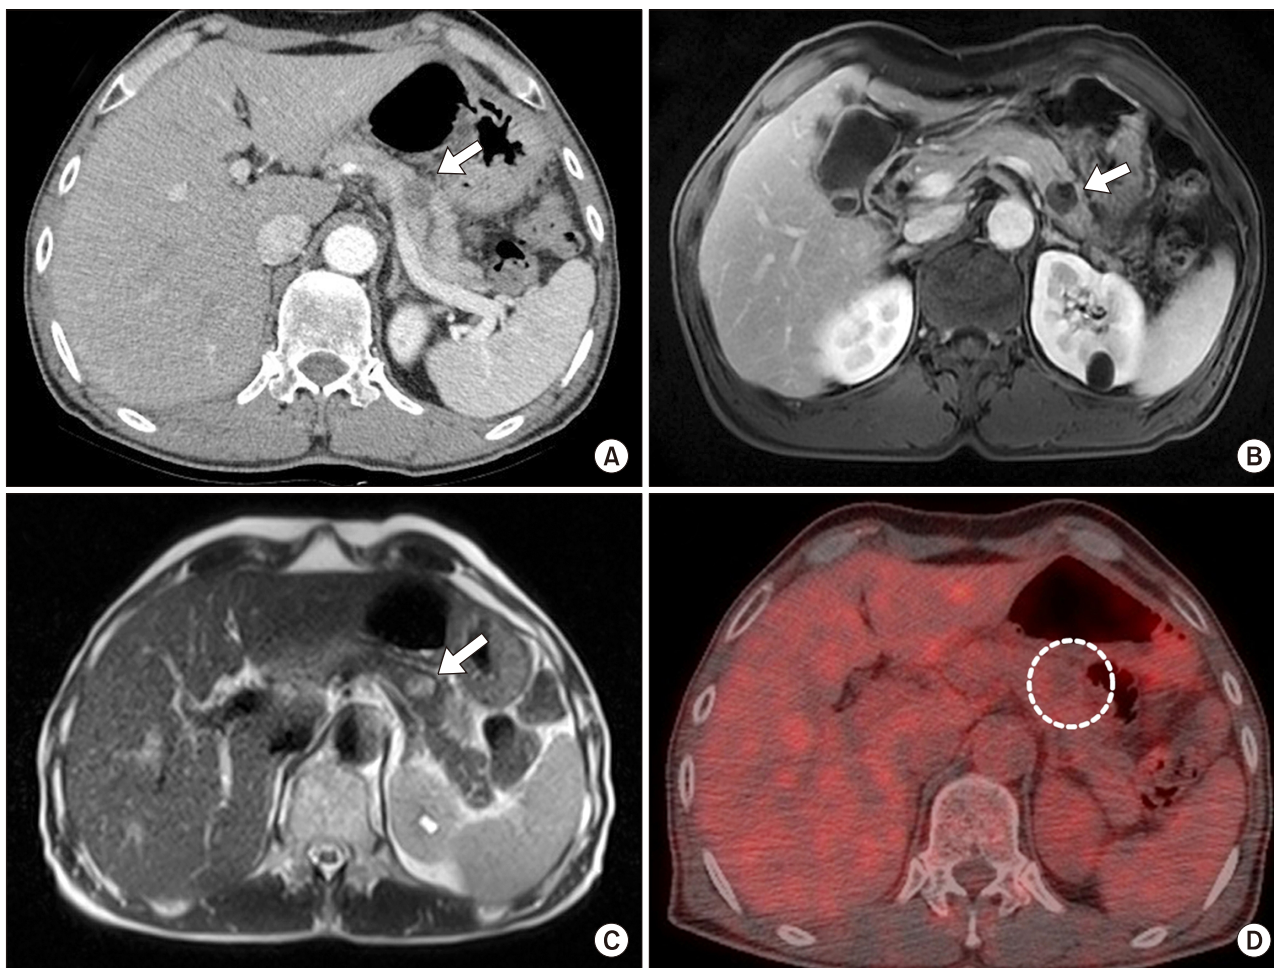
(A) Axial section of CT scan showing a round 1.8-cm sized cystic mass with upstream pancreatic duct dilation (arrow). (B) MRI showing a lesion with heterogeneous low intensity on T1-weighted images (arrow). (C) MRI showing a heterogeneous high intensity on T2-weighted images (arrow). (D) PET-CT showing no significant FDG uptake.
